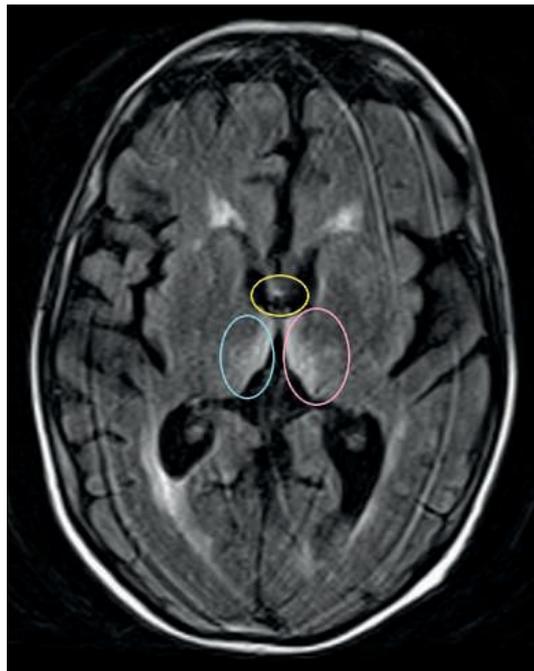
This is an MRI scan of an individual with WKS. It shows a ‘slice’ on the axial plane – moving from the top of the head, down to the brainstem. Brain scans are viewed as if you are looking in the mirror – the right side of the brain is on the left side of the scan. Atrophied mammillary bodies are circled in yellow, the thalamus of the left hemisphere circled in pink and of the right hemisphere circled in blue. The hypothalamus is not visible in this particular scan as they sit below the thalamus. Notice the right thalamus has degenerated more than the left.
